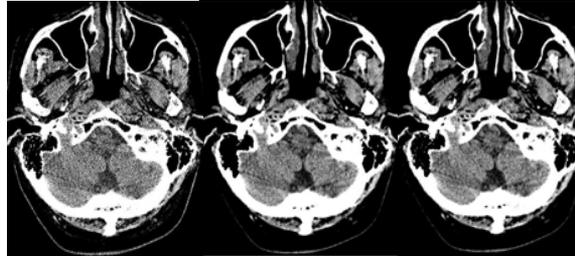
Brain window settings (W 80 L 40). Axial CT images obtained with bone (A), standard/soft tissue (B), and hybrid (C) convolution kernels.
